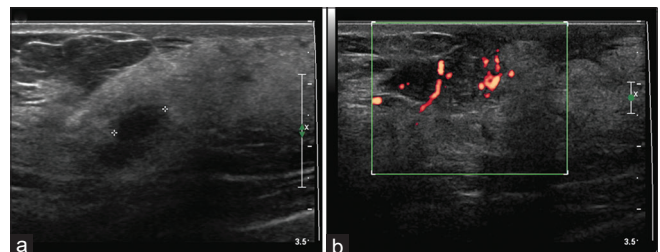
Follow-up transverse ultrasonography 2 weeks after the embolization shows residual small hematoma (a) with decreased size of pathologic confirmed granulomatous mastitis (b)
